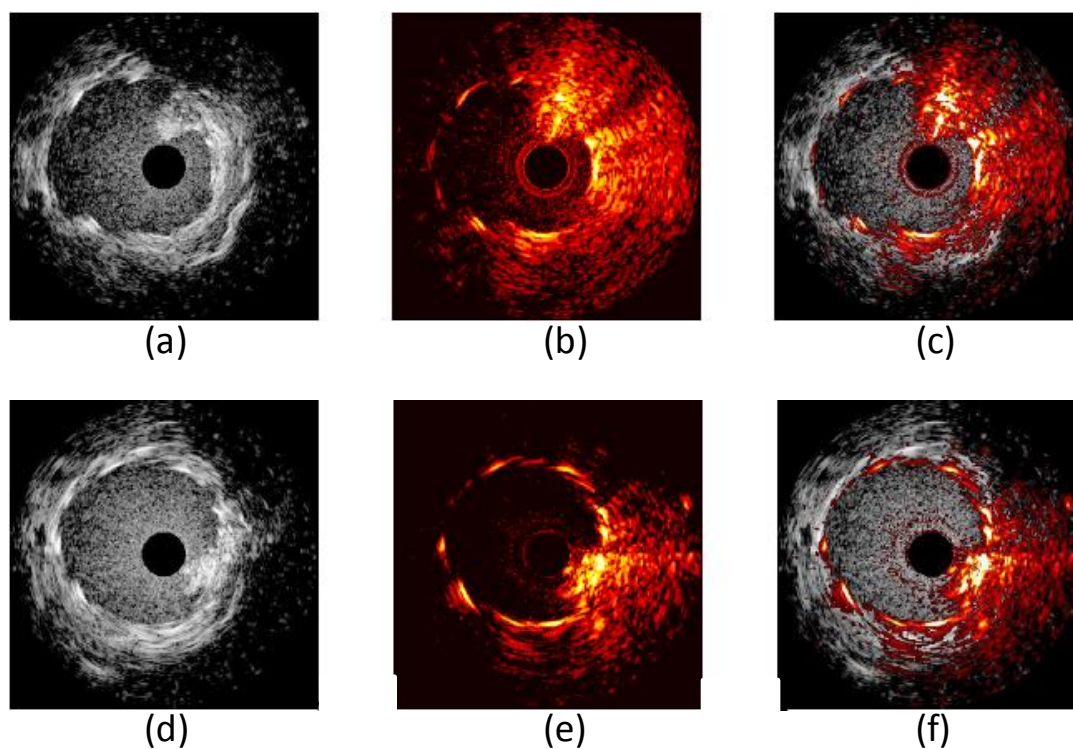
Ultrasound (left), photoacoustic (middle) and combined (right) images of rabbit's artery with freshly deployed stent. Upper and lower rows represent different cross-section of the artery.
